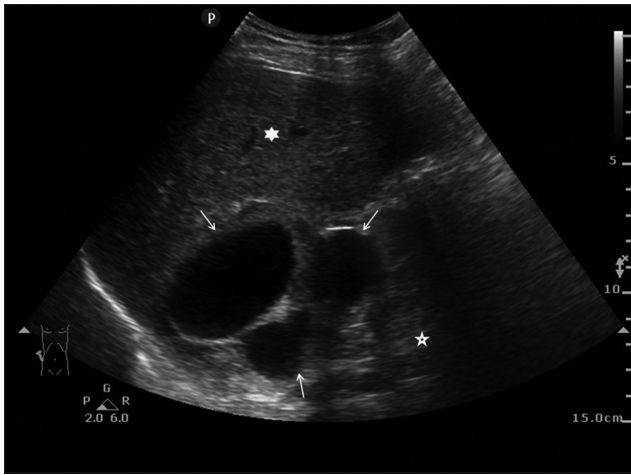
Point-of-care ultrasound image of the longitudinal plane showing multiloculated cystic mass (arrows), between the liver (asterix) and the right kidney (open star), with thick wall and septations
